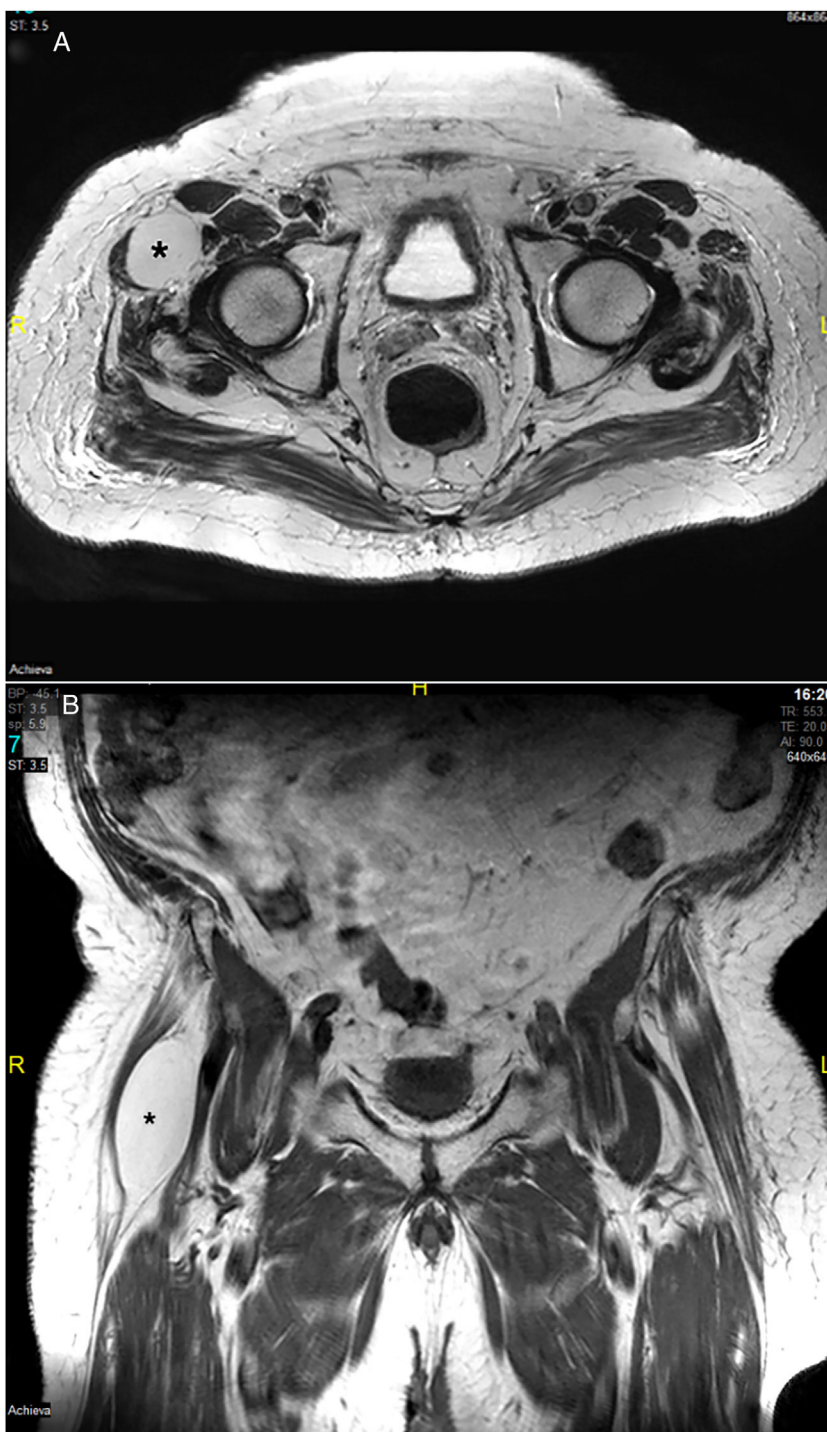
Ovoid lesion (*) between the belly of the fascia lata tensor muscle and the sartorius muscle. (A) Hip MRI, axial plane. (B) Hip MRI, coronal plane.
